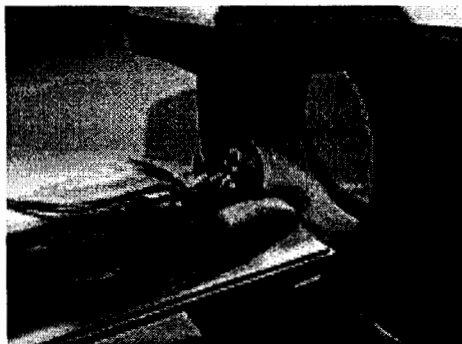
SPECT imaging machine [10]
